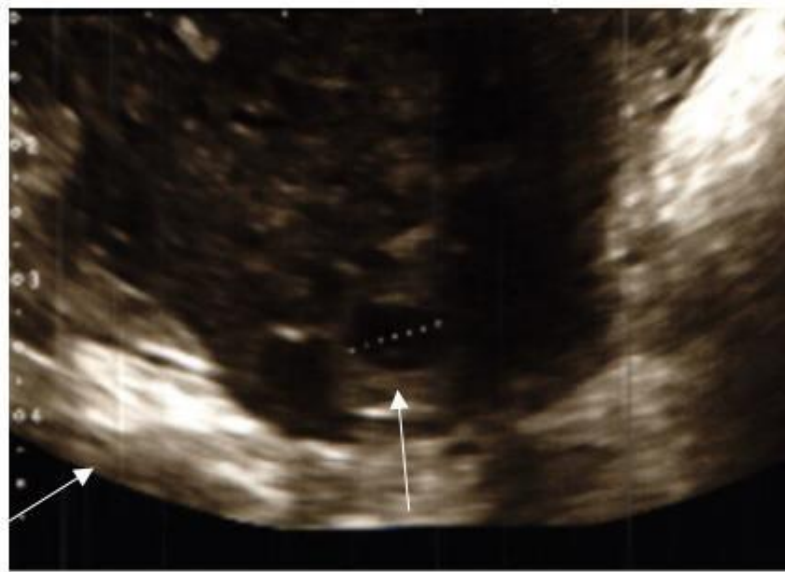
Ultrasound examination revealing a hematoma around the cornual region of the right fallopian tube.
